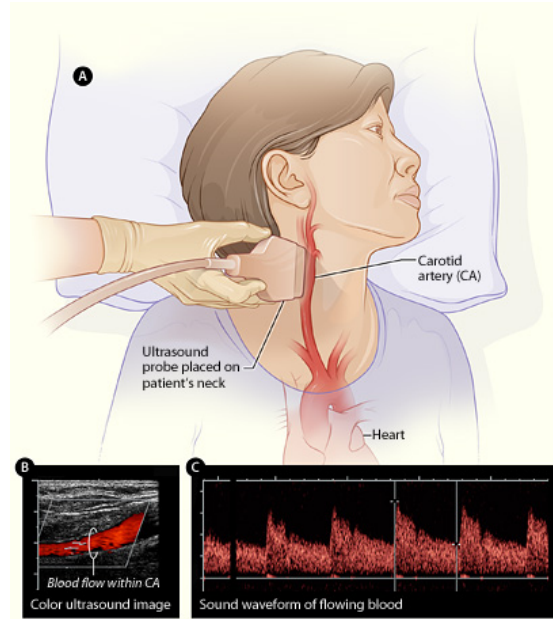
Carotid Ultrasonography implementation and results. a) shows the positioning of the wand by the operator over the sight of interest. b) shows the colour image generated from the results of US. c) shows the sound waveform representing the flow of blood in the artery. [34]
